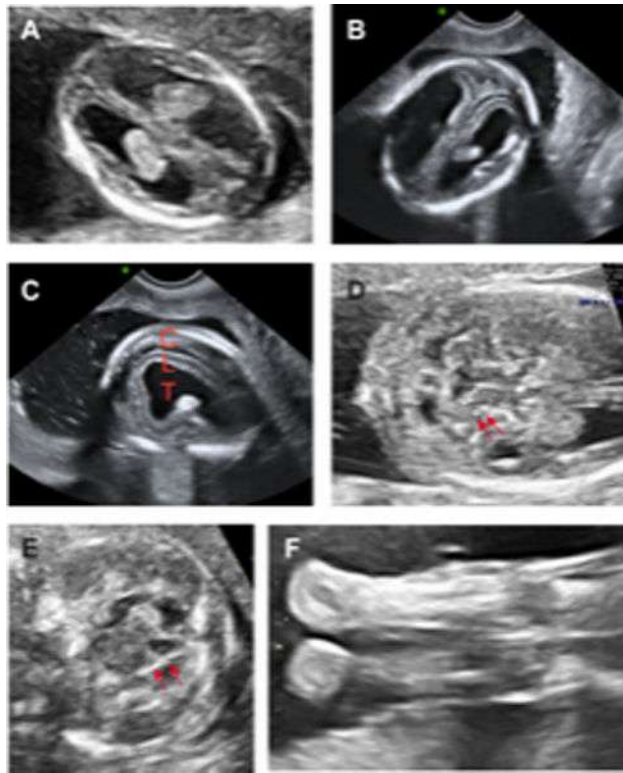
Fetal brain and limb abnormalities detected by prenatal ultrasound
